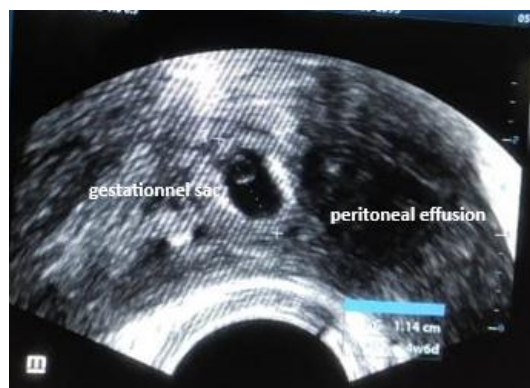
Transvaginal ultrasound showing a peritoneal effusion associated with a gestational sac.
